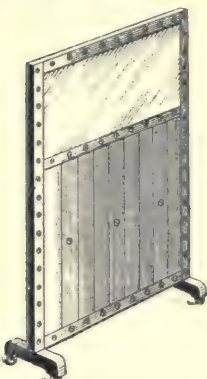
Screen opaque to X-rays.
